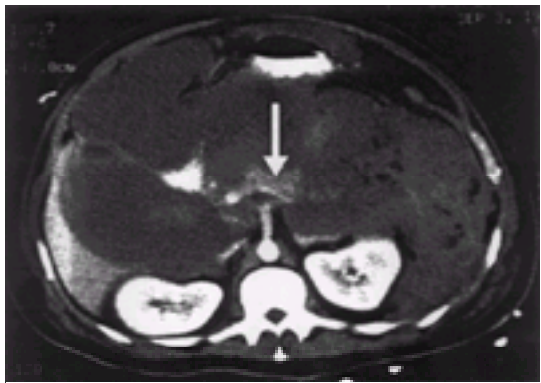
Helical CT scan of the abdomen revealing very little viable pancreas.
